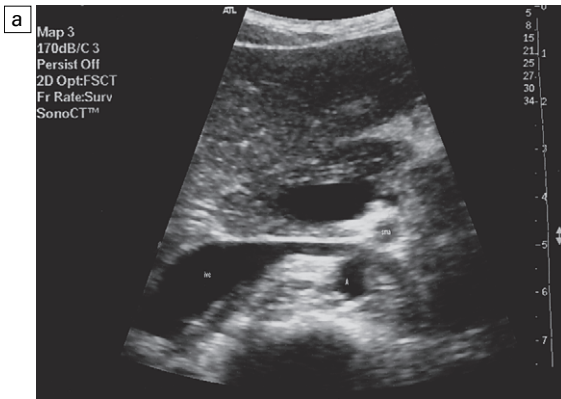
(a) The course of the left renal vein between the aorta and the superior mesenteric artery is demonstrated. (b) Colour flow Doppler demonstrating the left renal vein. Greater clarity has been achieved by a stomach distended with fluid.
